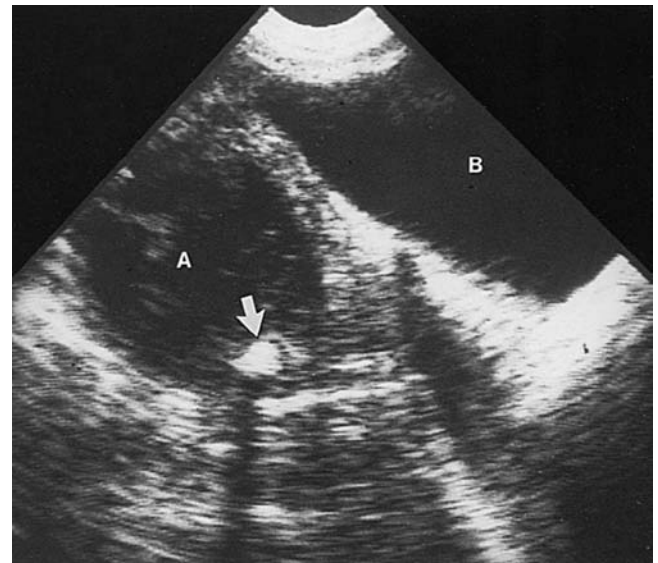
Perforated appendicitis with abscess and fecalith. Ultrasonography of the pelvis shows a complex mass (*A*) with a fecalith (*arrow*) producing characteristic acoustic shadowing to the right of the bladder (*B*).
